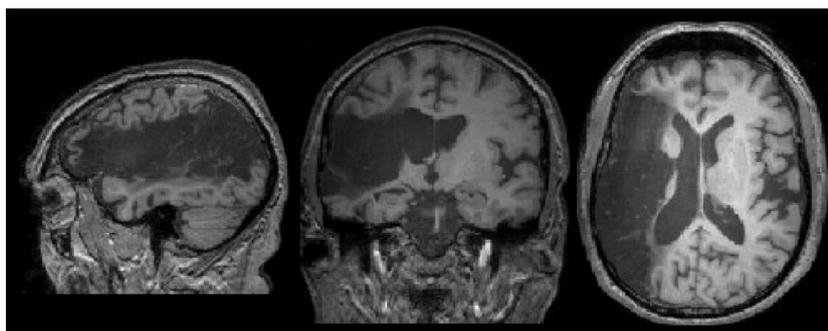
MRI scan for PR.
